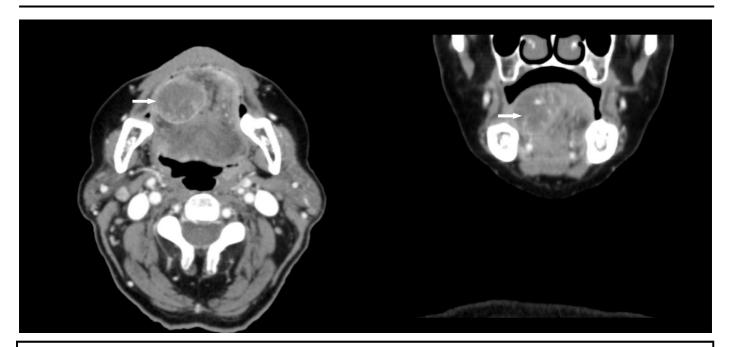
Axial and reformatted coronal CT sections of the tumor, which is blended in the intrinsic tongue muscles, with no involvement of the genioglossus and geniohyoid muscles, or the vasculonervous bundle.
